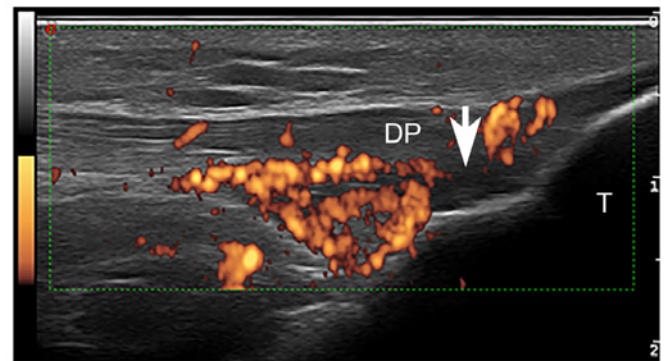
Power Doppler US image of the patellar tendon's distal enthesitis, revealing a hypoechoic tendon, with lack of a homogenous fibrillar pattern (arrow), mostly near to the cortical bone (<2 mm), with intense power Doppler signal. US, ultrasonography; T, tibial tuberosity; DP, distal patellar tendon (Esaote, MyLab25 18 MHz).
